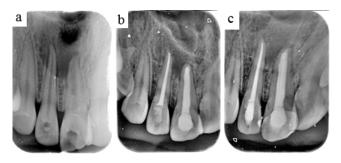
a: Preoperative; b: postoperative; c: and 6 months follow up radiographs
